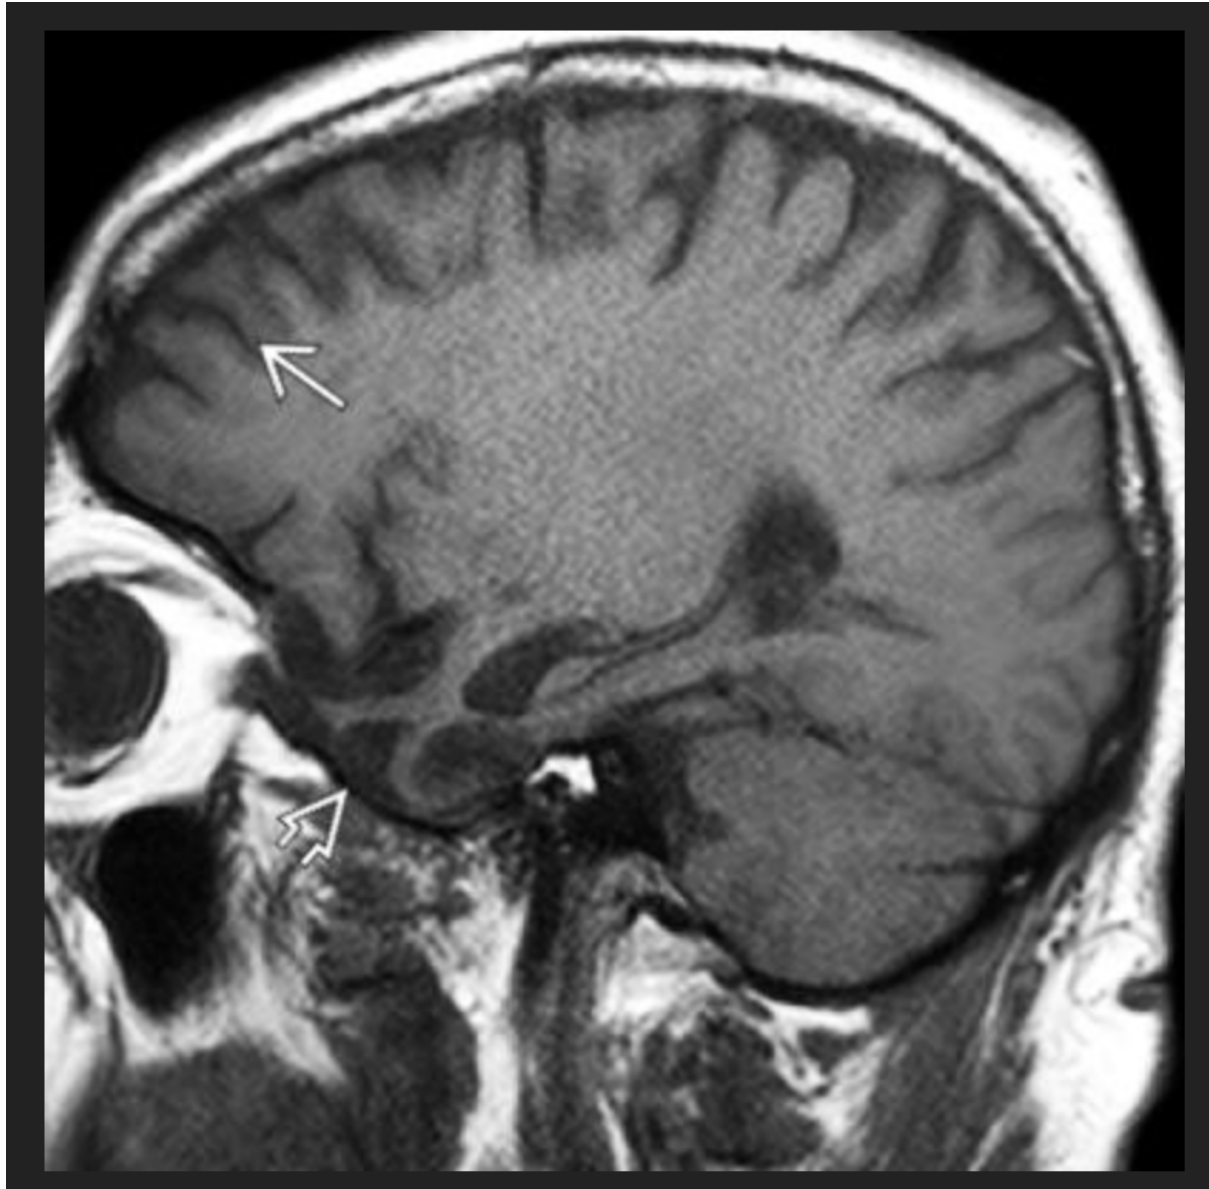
63-year old man with Semantic Dementia. MRI showed striking temporal lobe volume loss with relatively well-preserved frontal gyri ¹⁰⁸.
